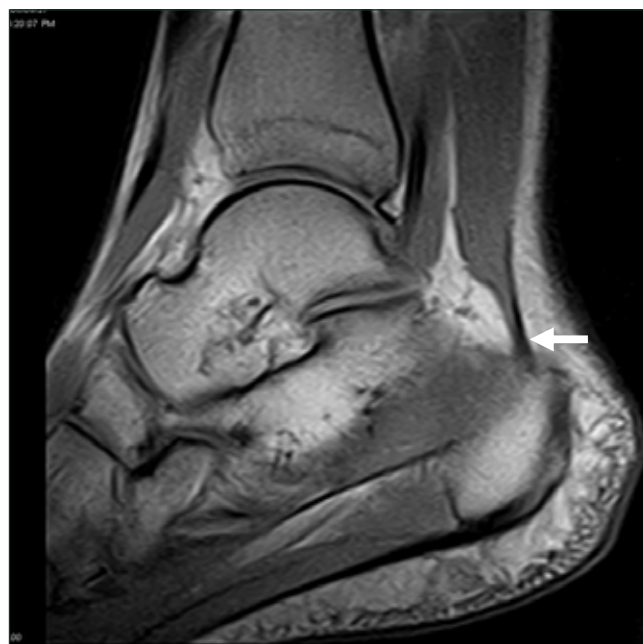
Left ankle MRI: posteromedial insertion (arrow) of the accessory soleus muscle onto the calcaneus via a thin tendon.
